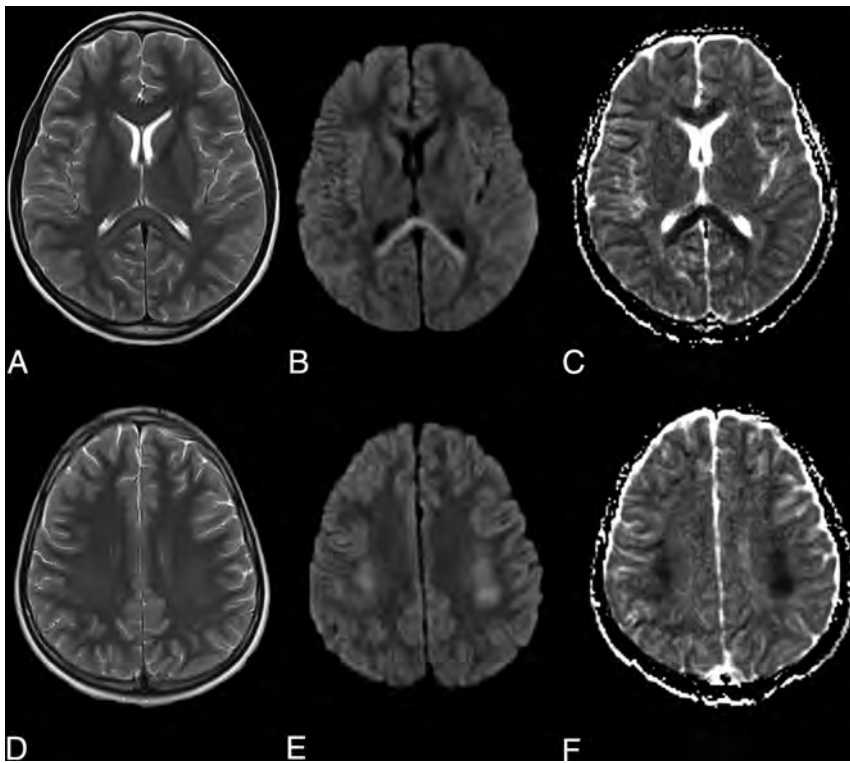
Axial MR images demonstrate T2-weighted hyperintensity in the splenium and genu of the corpus callosum (A) and symmetrically in the deep cerebral white matter (B) with associated restricted diffusion on the DWI (B and E) and ADC maps (C and F).
